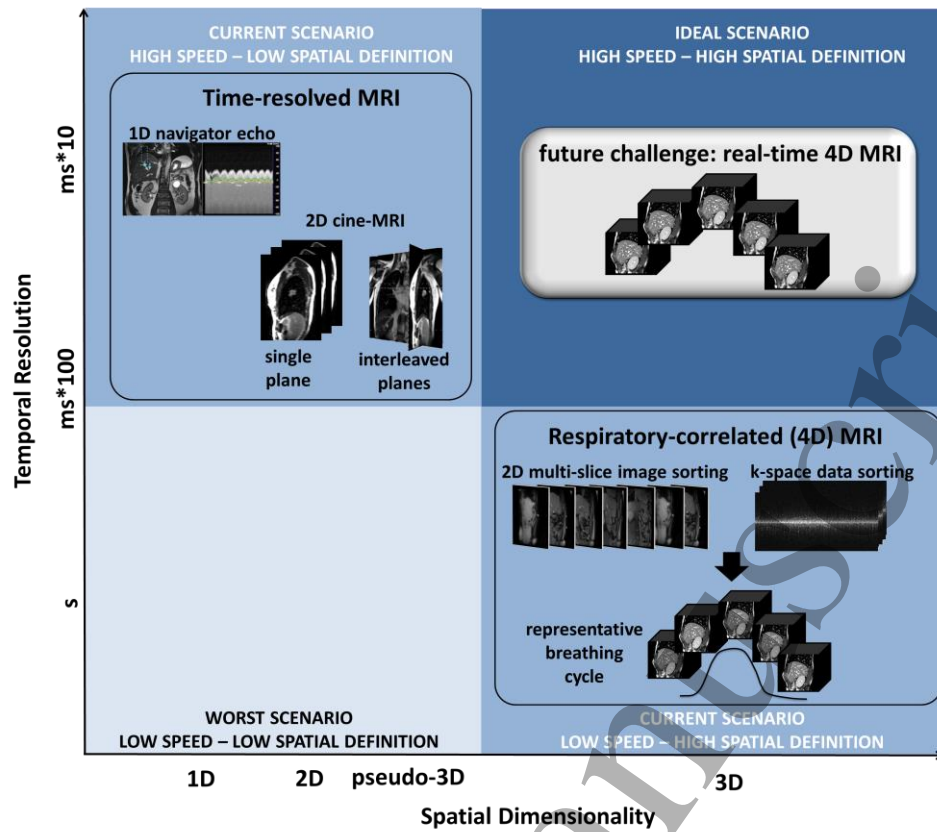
Image acquisition approaches in terms of temporal resolution vs. spatial dimensionality. The ideal acquisition strategy would yield real-time 4D MRI; at present this is not possible and remains a future challenge.
